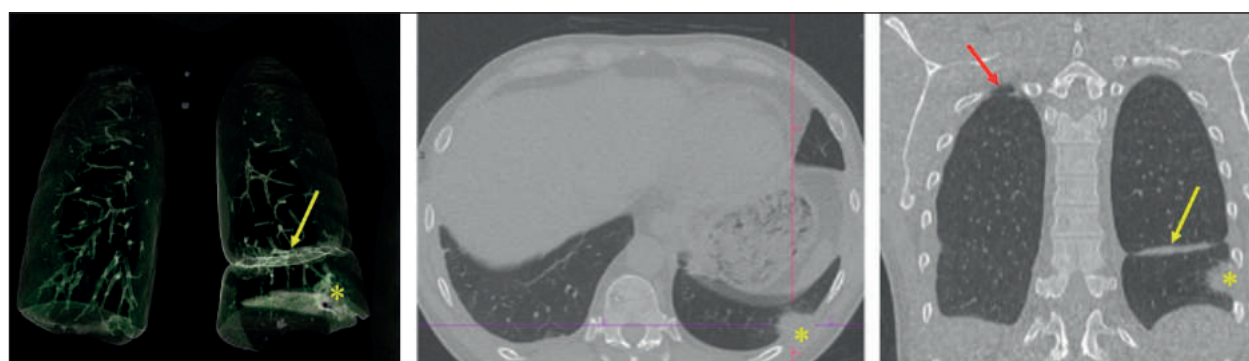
Computed tomography of the chest: discrete scars in the apical part of the right lung (red arrow), subpleural nodule (asterisk), and linear atelectasis in S10 on the left (yellow arrow).
